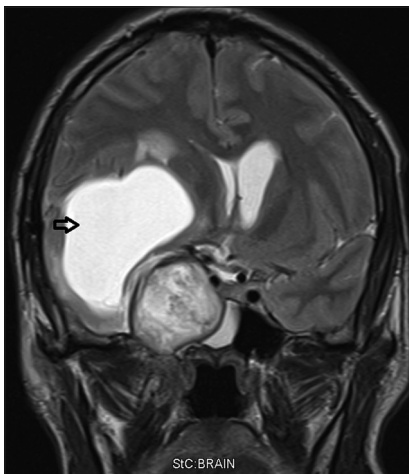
Coronal magnetic resonance imaging brain with contrast showing extra-axial heterogenous mass in the right parasellar region bounded medially by the internal carotid artery and cavernous sinus, Superiorly by the middle cerebral artery laterally by the temporal lobe and a newly formed cyst (arrow) in the previously dissected surgical corridor.
